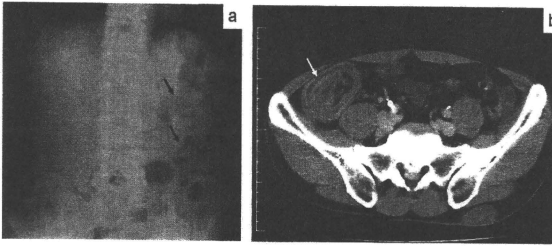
Radiologic findings: (a) an abdominal X-ray film shows marked intestinal dilatation (arrows) and (b) computed tomography reveals intussusception in the ileum, which leads to target sign (arrow).
